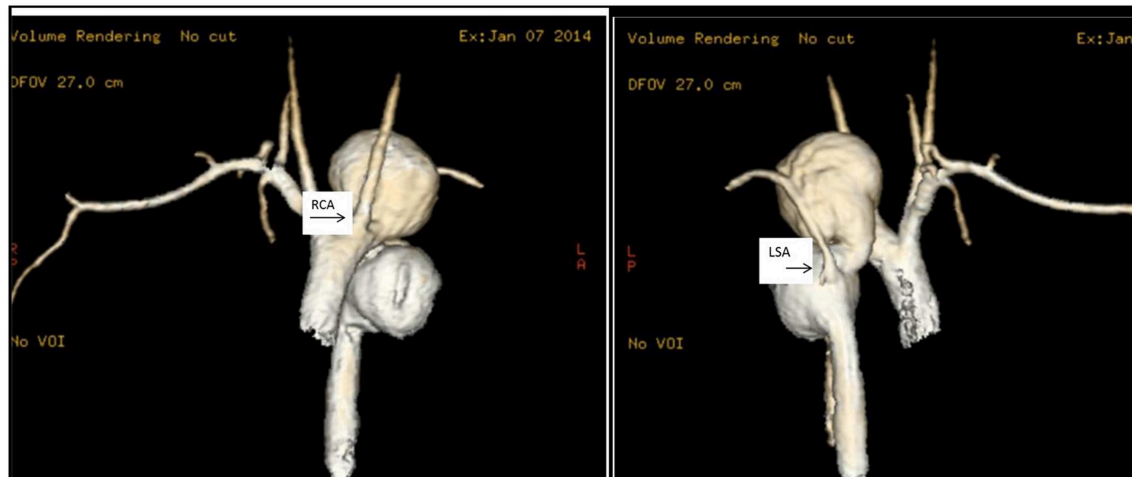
Thoracic aorta aneurysms. MRI scans of the ascending aorta in a 17 year old girl with multiple thoracic aortic aneurysms. In (i), it is clearly visible a large saccular aneurysm of the aortic arch just distal to the right carotid artery (RCA) and a second large saccular
